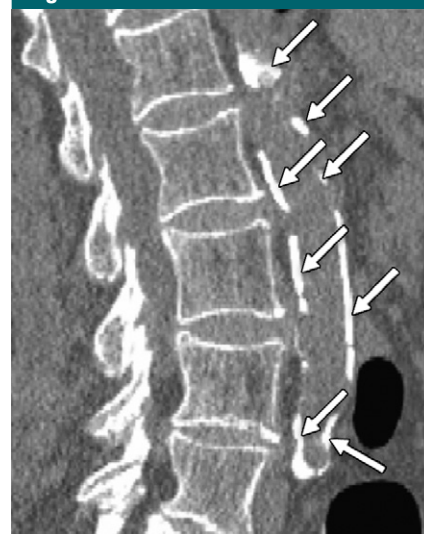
Sagittal section of L1–L5 vertebrae from a CT colonography image of an 85-year-old woman shows appreciable aortic calcification (arrows), which contributed to discrepancies that caused the patient to just miss testing positive for spine osteoporosis at DXA (T = -2.4); however, she definitively tested positive for both spine osteoporosis (vertebral trabecular BMD, 71 mg/cm³) and fragile bone strength (vertebral strength, 3220 N) at biomechanical CT analysis.
